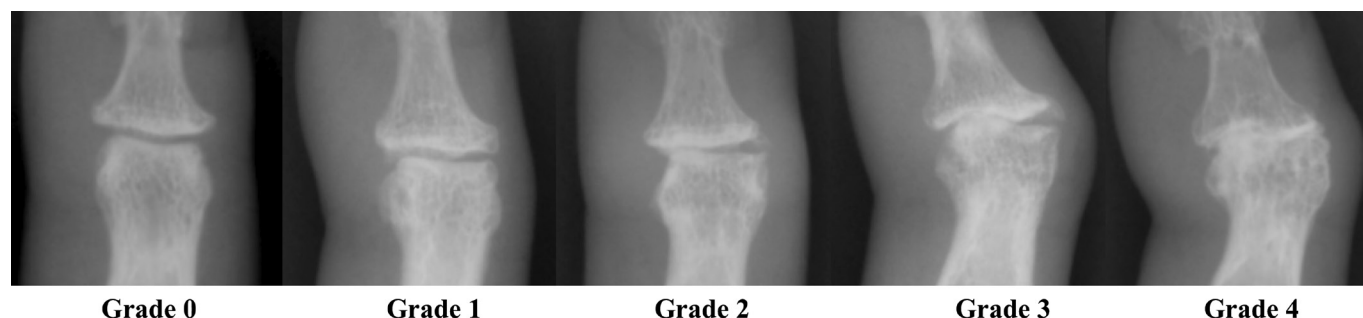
Representative examples of KL grade of RHOA. KL, Kellgren-Lawrence; RHOA, radiographic hand osteoarthritis.
